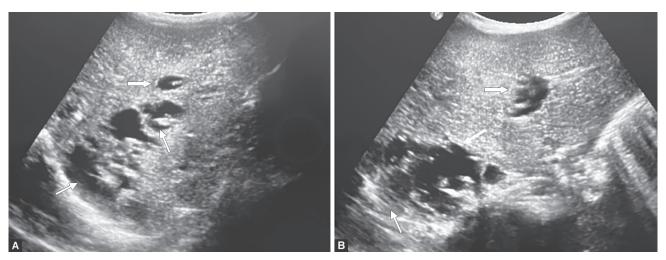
(A) Longitudinal; and (B) Transverse sonographic images of the right kidney (arrows) showing an enlarged kidney (for her age; arrows) with increased echogenicity, multiple cysts of varying sizes (*), and loss of normal corticomedullary differentiation. These findings were consistent with ARPKD
